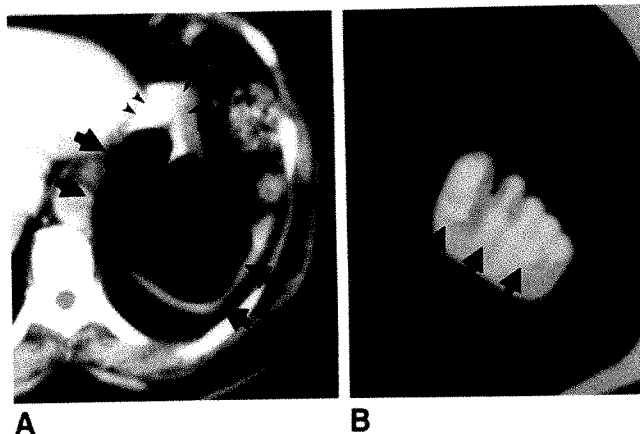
A, Postcontrast CT scan shows low-attenuation pseudomass in left upper quadrant (arrows) extending beyond borders of stomach (arrowheads).
